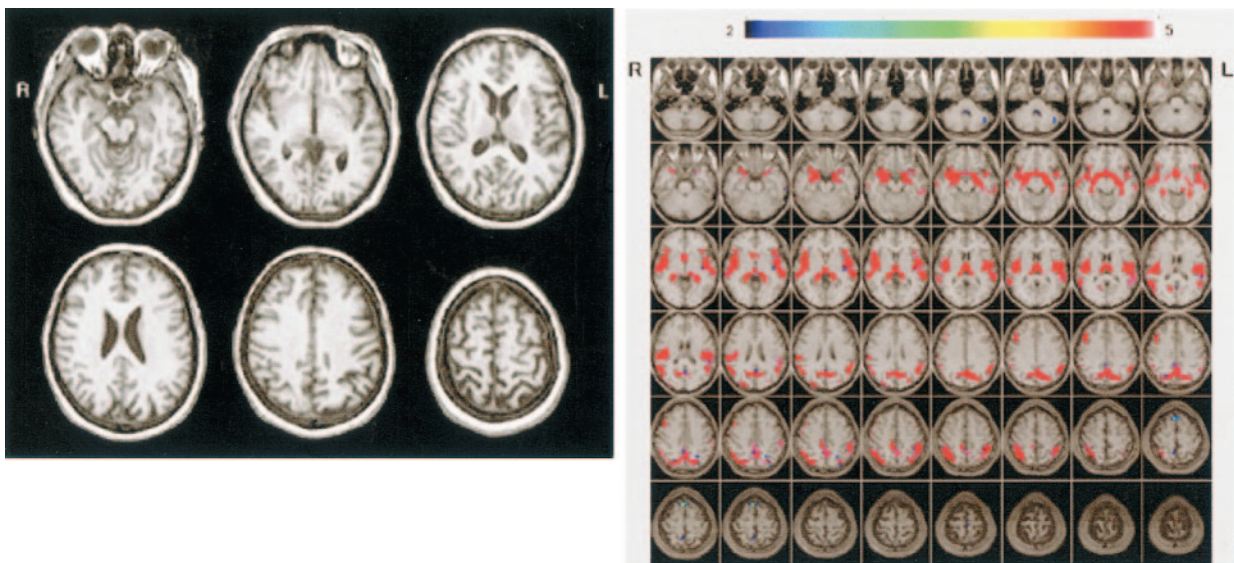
A and B, Conventional MR images (A) and Z score images (B) obtained in a 57-year-old healthy subject (MMSE score = 30). No atrophy is apparent on the MR images, and there are no areas with Z score greater than 2 overlaid on the prototypic early-onset AD template map. L indicates left; R, right.
